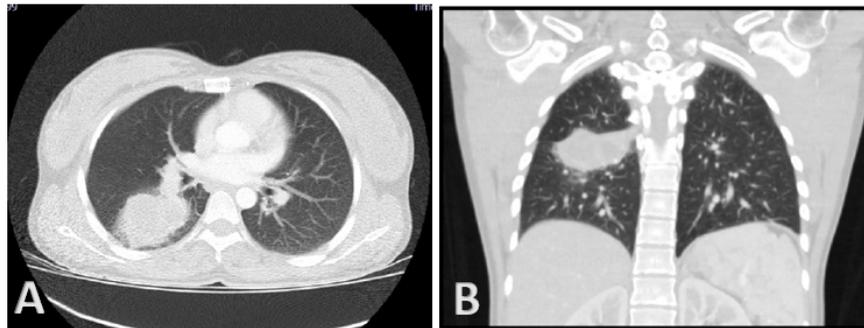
A. Axial computed tomography view, showing an increase in the abscessed lesion in the upper segment of the lower lobe on the right side. B. Coronal computed tomography view.
